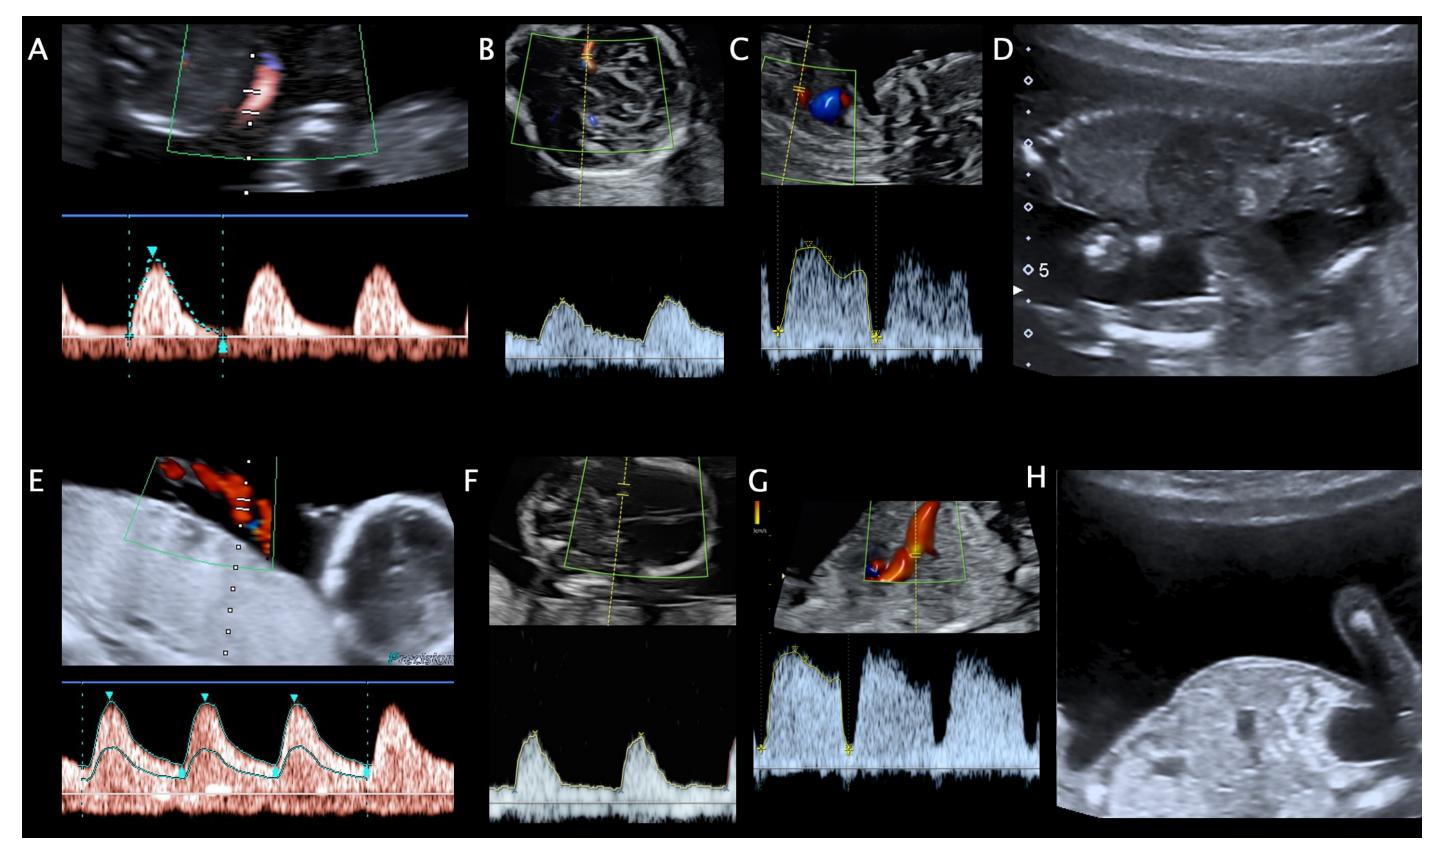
Ultrasound findings at week 15+1 before fetoscopic laser ablation, A)-D) Donor, E)-H) Recipient; A) UA-PI: 2.56, EDF positive B) MCA-PI: 1.75, PSV: 16.1 cm/s C) DV-PIV: 1.22 D) Oligohydramnios, deepest pocket: 1.5cm E) UA-PI: 1.37, EDF negative F) MCA-PI: 1.19, PSV: 23 cm/s G) DV-PIV: 1.11 H) Polyhydramnios, deepest pocket: 7.2cm;
